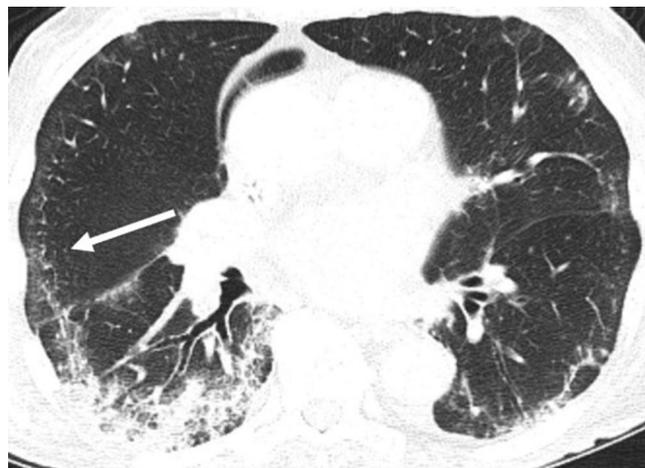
79-year-old woman with advanced cervical adenocarcinoma treated with pembrolizumab, with moderate liver function test elevation. Restaging CT of the chest shows peripheral ground-glass opacities with subpleural sparing consistent with an NSIP pattern (arrow), not visible on prior scans (not shown). Findings were thought to be related to immune-mediated pneumonitis.
